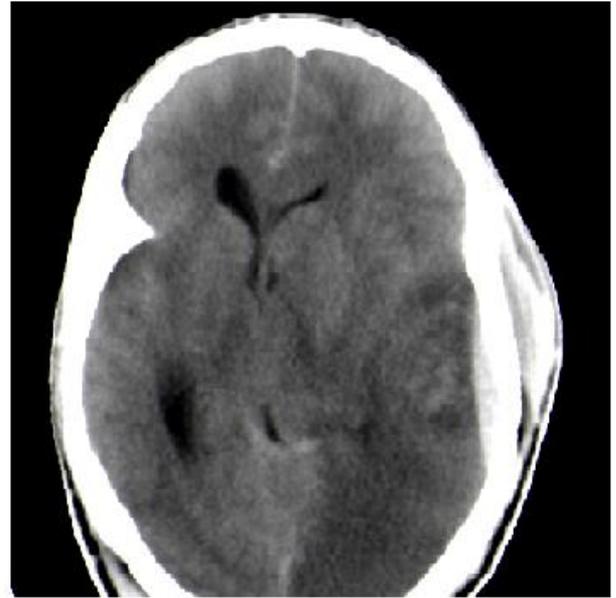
to 8 demonstrate the CT findings in patients with various GCS at presentation and mechanisms of injury.
